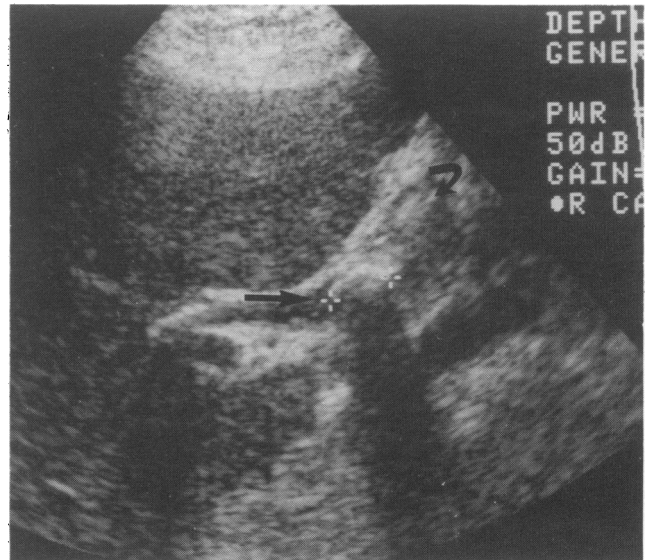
Ultrasound showing a stone with distal acoustic enhancement (straight arrow) within a dilated common duct (curved arrow).
